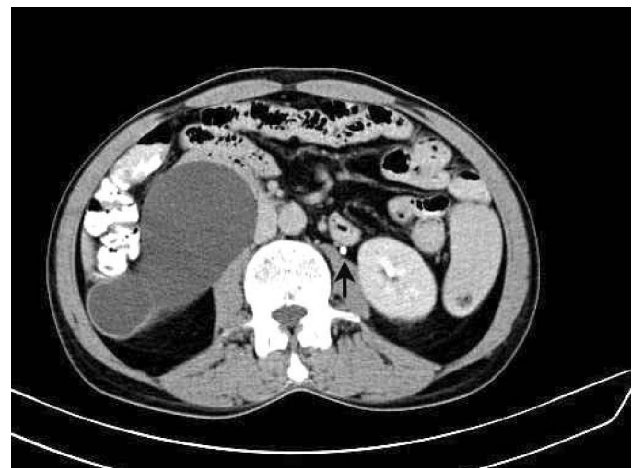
Delayed CT scan shows little or no contrast enhancement in the right kidney and no contrast material excretion is seen in the right ureter. Left ureter has opacified normally with contrast (arrow).
